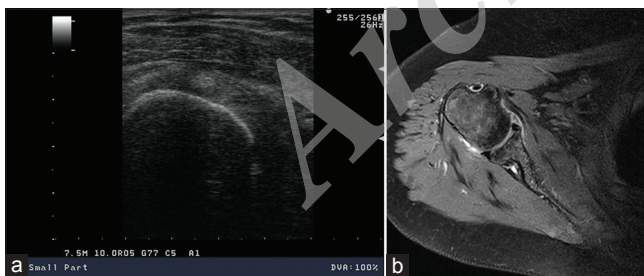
(a) Short-axis ultrasound image showing normal biceps tendon. (b) PD-weighted axial image showing normal biceps tendon
